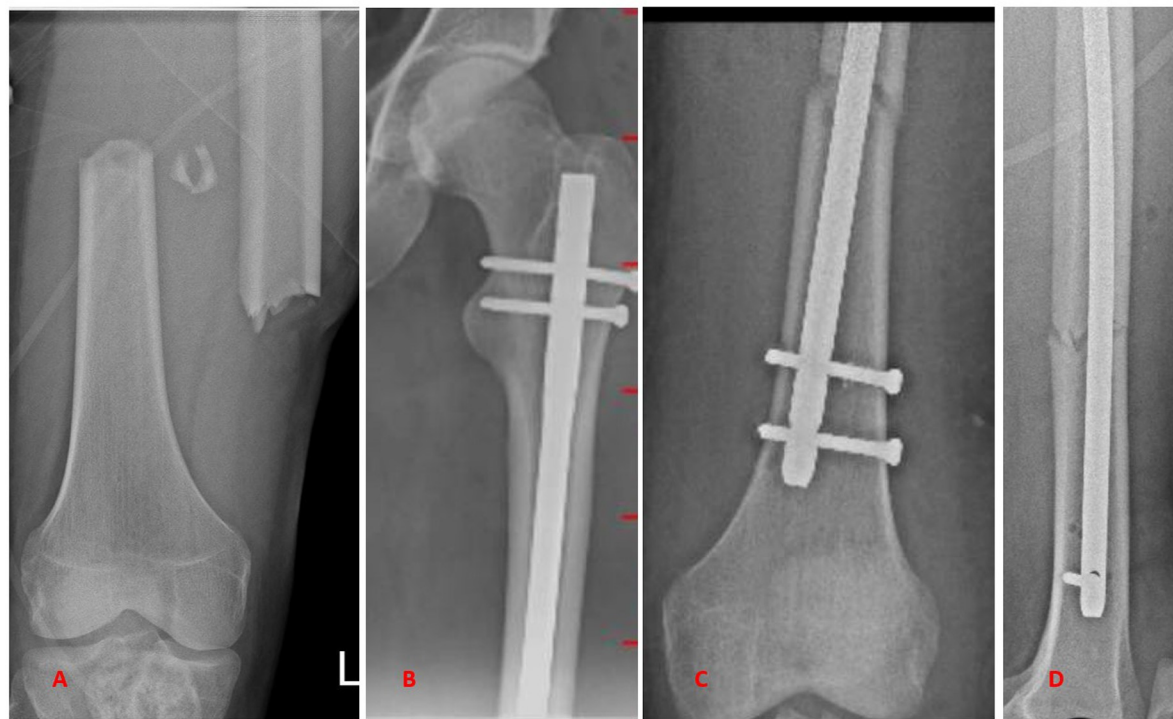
Radiographs of a 32-year-old man with femur shaft fracture (A) managed by static intramedullary nailing at 28 weeks (C, D, E), united at 34 weeks.
